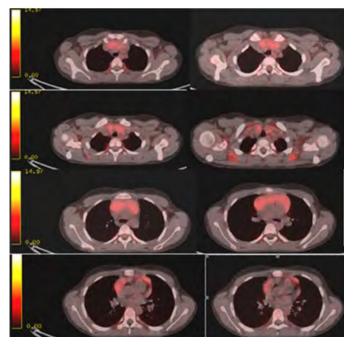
18F-FDG PET/ CT from January 2023-Persistence of the retrosteneal formation in the front mediastinum, which now presents more formulated, with lobulated contours and a homogeneous metabolic activity SUV max 3.3.
